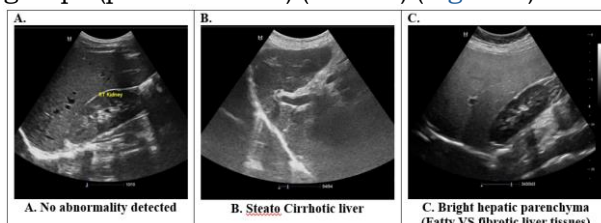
Grading of hepatic parenchymal changes of liver tissues by ultrasound
